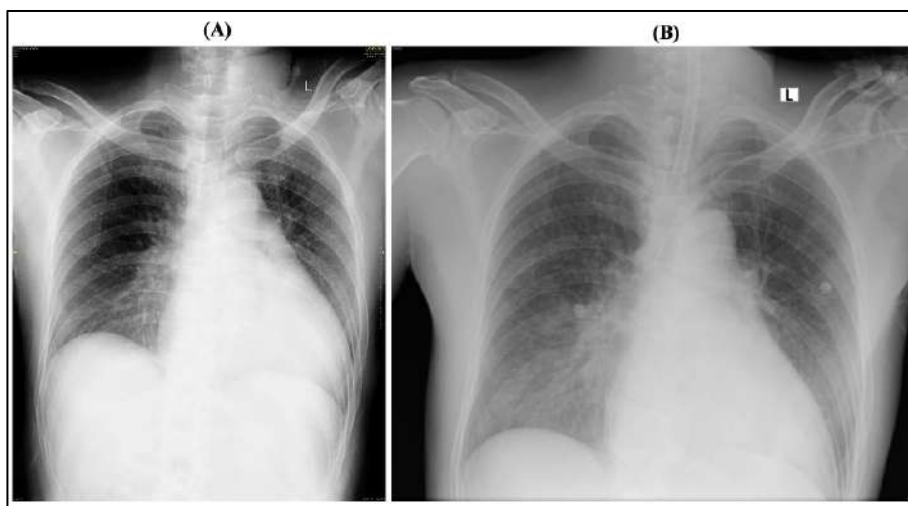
(A). Pre-operative chest x-ray; (B) Post-operative chest x-ray on day 4
